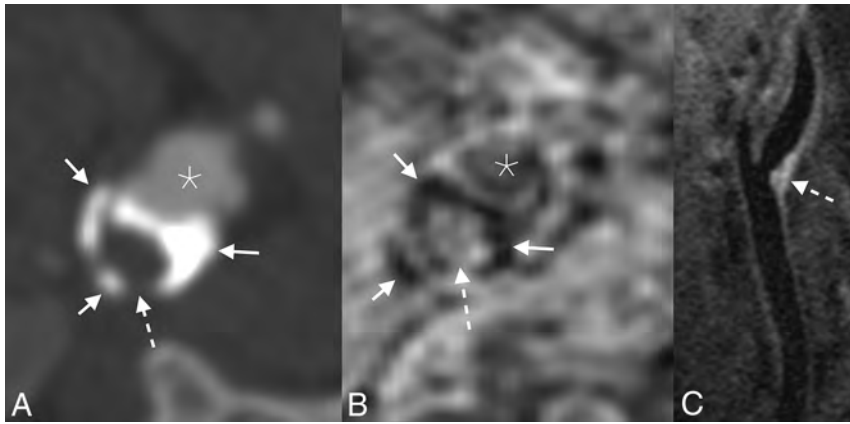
Example of an LRNC. Axial CTA image (A) demonstrates a peripherally calcified (*solid arrows*) plaque with a soft interior (*dashed arrow*). The corresponding axial-reformatted MPRAGE image (B) similarly demonstrates areas of calcifications with markedly low signal (*solid arrows*); the plaque interior lacks bright signal, ruling out hemorrhage (*dashed arrow*). T1 fat-saturated Cube image (C) shows hyperintense signal in the plaque interior (*dashed arrow*), compatible with an LRNC. Asterisks denote the vessel lumen.
